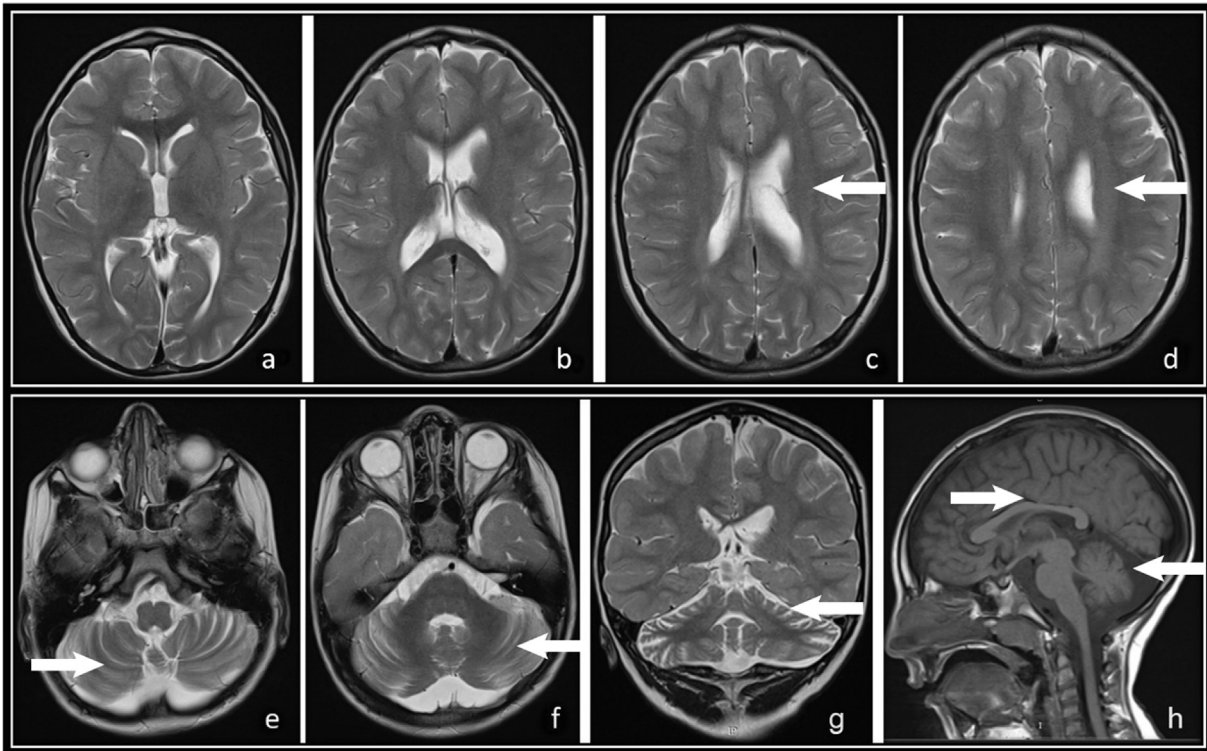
Patient 3 – T2-weighted axial sections (a, b, c, d, e, f), T2-weighted coronal section (g) and T1-weighted sagittal section (h) from an MRI scan taken after the first seizure. Linear hyperintensity of central white matter is highlighted (c, d), alongside mild cerebellar atrophy (e, f, g, h) and thinning of the corpus callosum (h).
